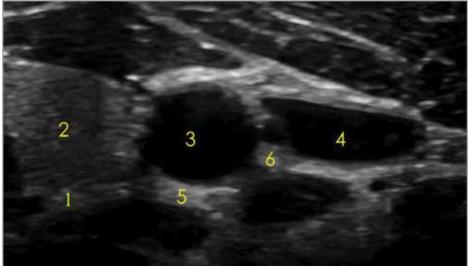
Ultrasound image at the level of the cricoid cartilage. 1) Recurrent laryngeal nerve, 2) thyroid lobe, 3) carotid artery, 4) internal jugular vein, 5) stellage ganglion, 6) vagus nerve. The trachea is just medial to this image.
